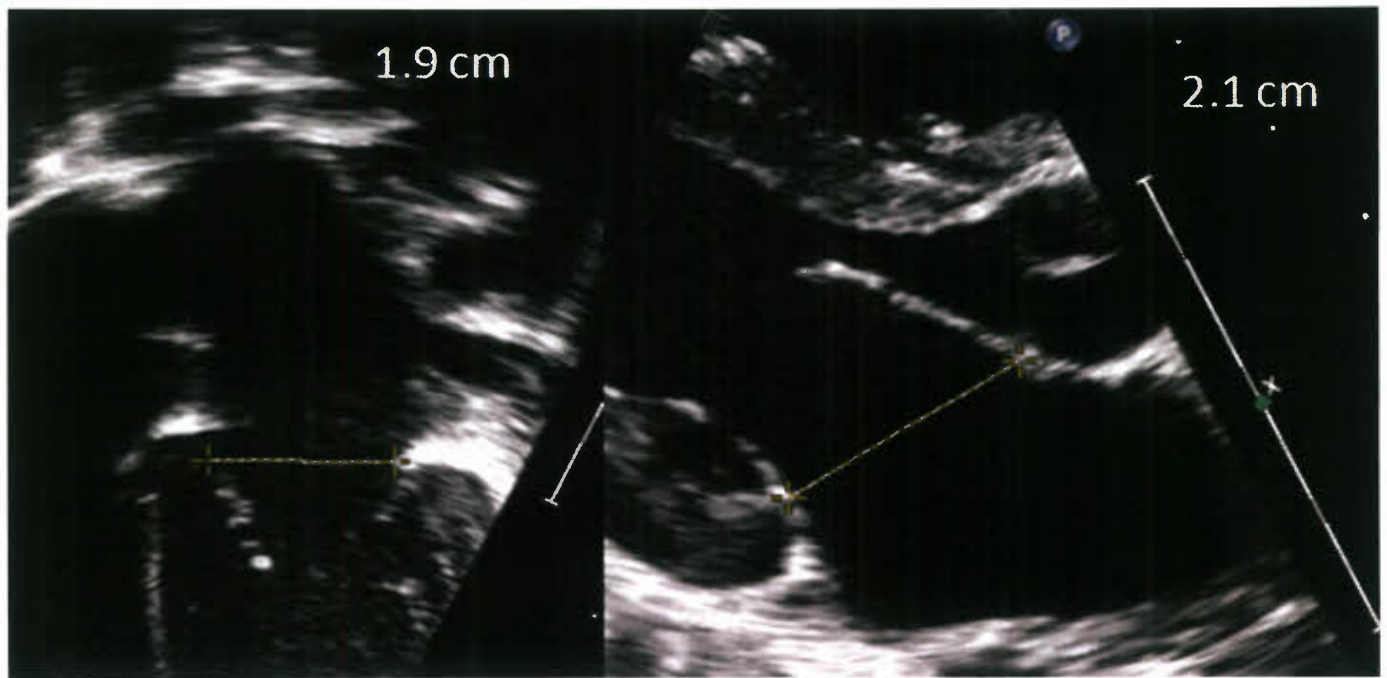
Measurement of the mitral valve in two planes. Left panel shows the apical four-chamber view and right panel the parasternal long-axis view. The valve is measured in diastole with the leaflets open.
